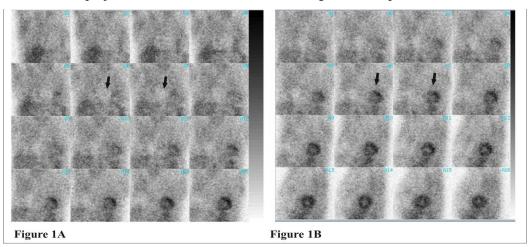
First 16 projections of the first rest SPECT data. Figure 1B. First 16 projections of the second rest SPECT data.
